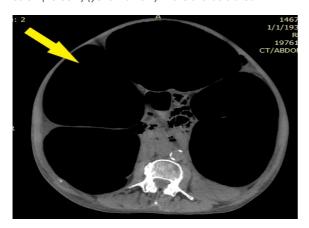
abdominopelvic CT scan showing the magnitude of the dilated colon (yellow arrow pointing at the dilated transverse colon)
